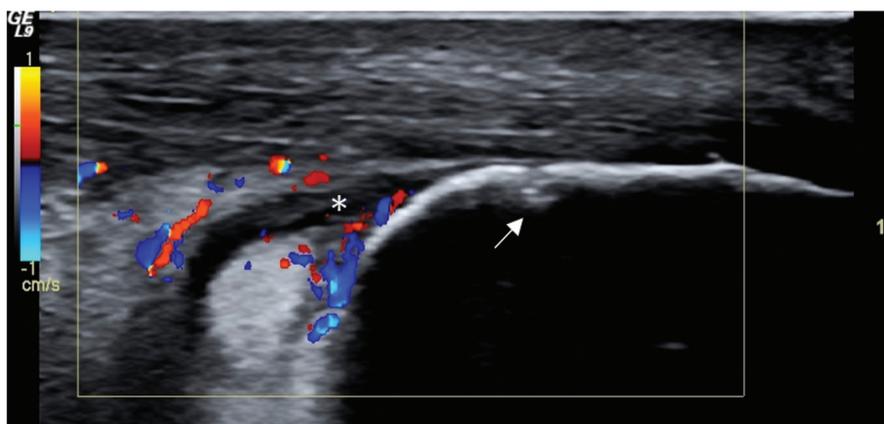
Ultrasonographic appearance of enthesal Achilles insertion. Bursal enlargement with Doppler signal (*), and erosion (arrow) in a longitudinal view.
